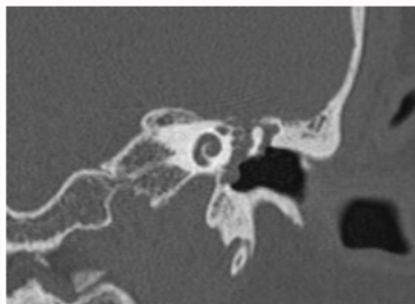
HRCT temporal bone, coronal cut showing defect in tegmen antri.
